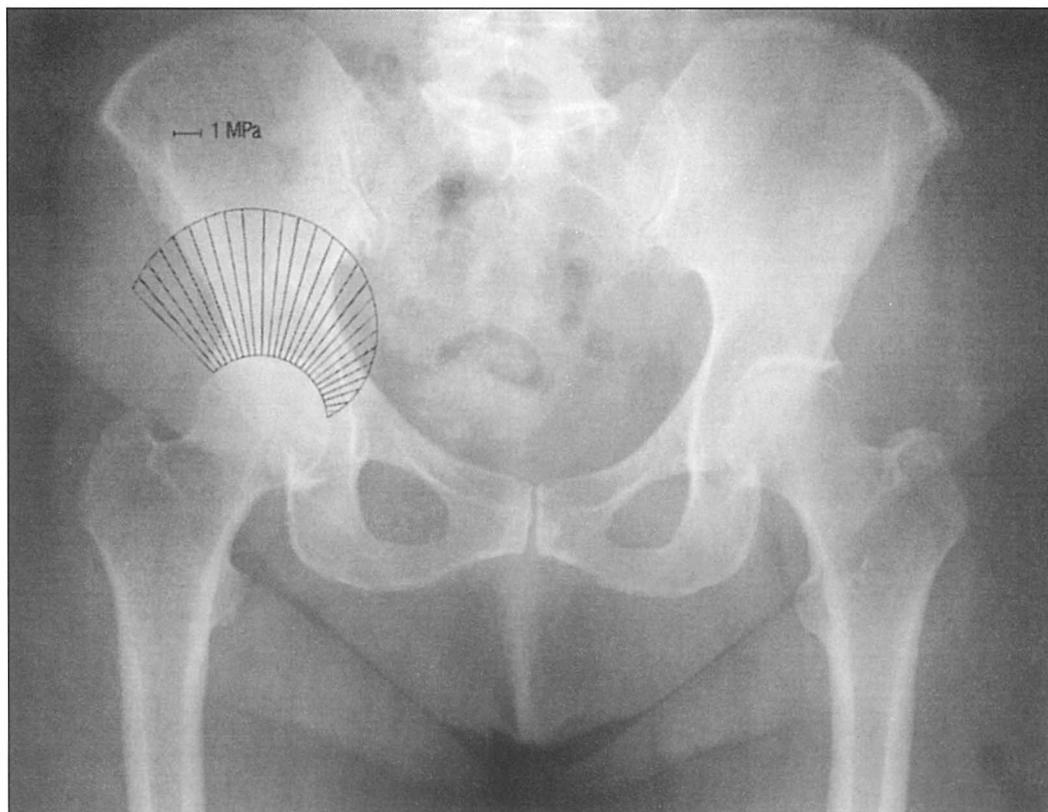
shows the calculated hip joint contact stress distribution in the female hip (age 76). The AP radiograph was taken from the archives of the authors.
